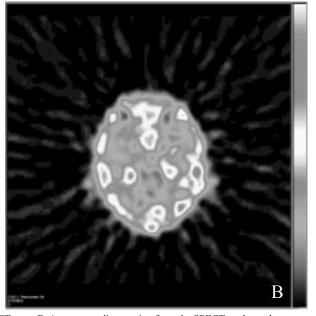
A. Coronal section of a low-grade glioma of medulla as seen on CT scan. B. A corresponding section from the SPECT study on the same patient shows no tracer concentration.
